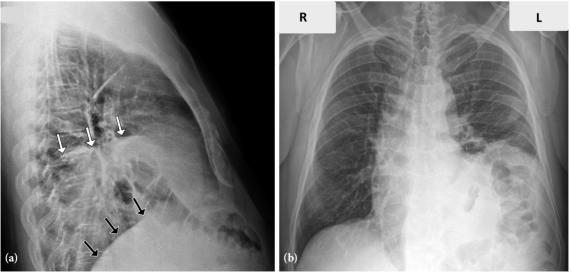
(a) Lateral and (b) posteroanterior chest radiographs demonstrating elevation of the left hemidiaphragm.
